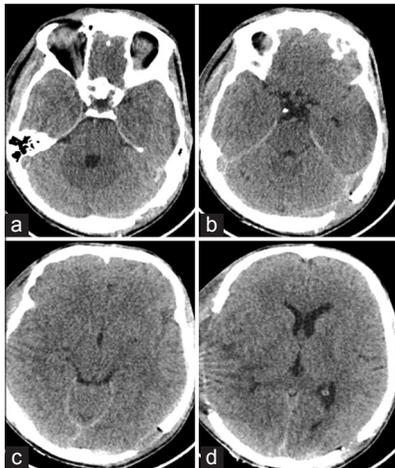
(a-d) Post-operative axial plan cranial computed tomography showing evacuation of the epidural hematoma after the second operation on the left occipital region of the brain and on the left side of the posterior fossa
